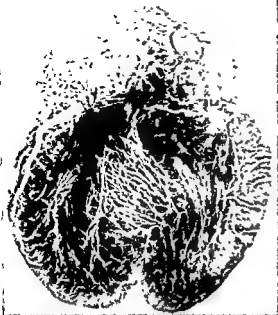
3 Roentgenogram of injected heart showing distribution of deeper divisions of coronary arteries (From Gross, 1921 [Figure 5, p 17]. Courtesy of Paul B. Hoeber)
